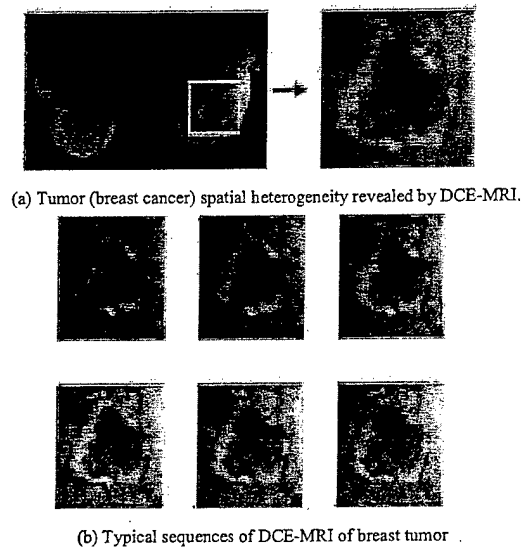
(a) Tumor (breast cancer) spatial heterogeneity revealed by DCE-MRI; (b) Sequences of the breast tumor ROI.
